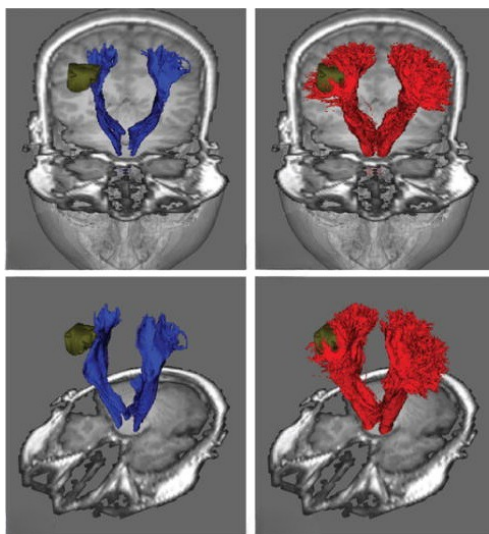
Fiber bundle reconstructions from DTI-based (blue) and CSD-based (red) tractography algorithms in the same patient dataset. Bundles are overlaid on coronal T1-weighted images with a right cortical lesion (green). CSD tractography reveals more lesion-surrounding corticospinal fibers than the DTI-based reconstruction. Figure adapted from [8].
